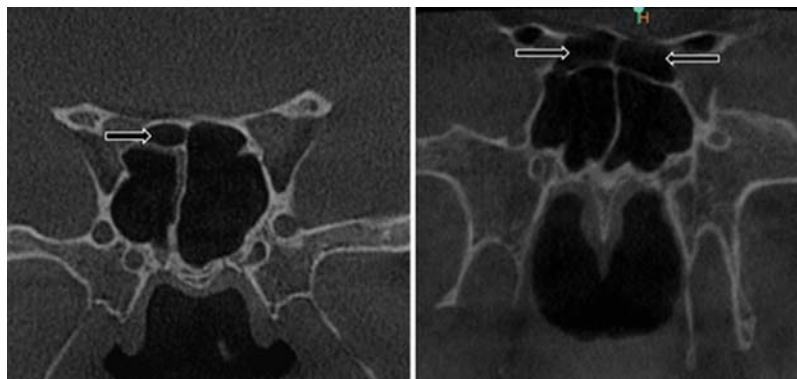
Cone-beam computed tomography (CBCT) scan in coronal view showing Onodi cells (black arrows).
